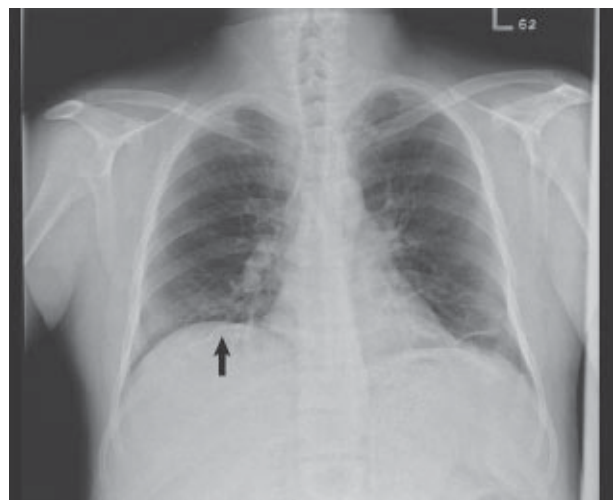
Chest X-ray shows elevated right hemidiaphragm and passive atelectasis of the right lower lung (arrow).
